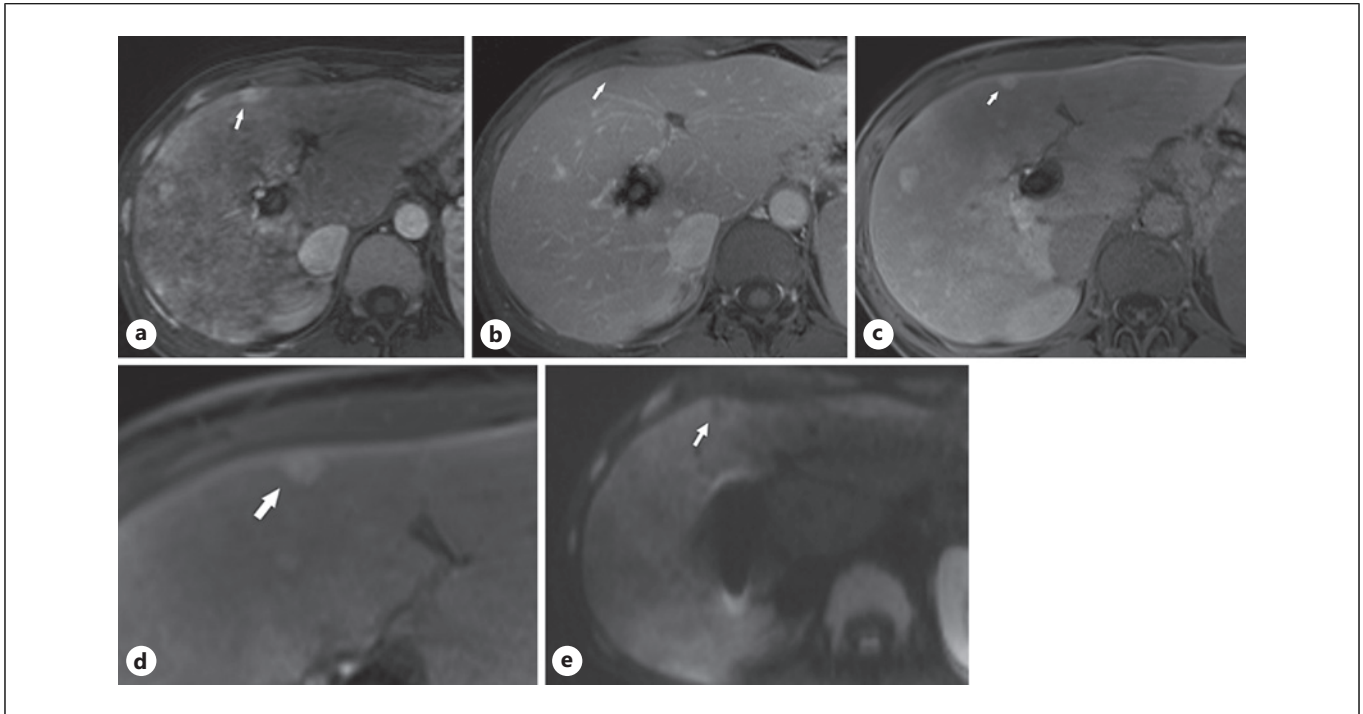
Detection of central scar in the HBP in a nodule that was suspicious on MRI with extracellular contrast (arrows). EC-MRI arterial (a) and delayed venous phase (b). c, d HB-MRI HBP. e DWI with high b value. APHE (a) and subtle washout in the venous phase (b). c Contrast uptake in the HBP. d Detail of the HBP showing the central hypointense linear scar (characteristic of focal nodular hyperplasia). This linear scar was not detected in the EC-MRI. e The nodule is hypointense in high b DWI sequences.
